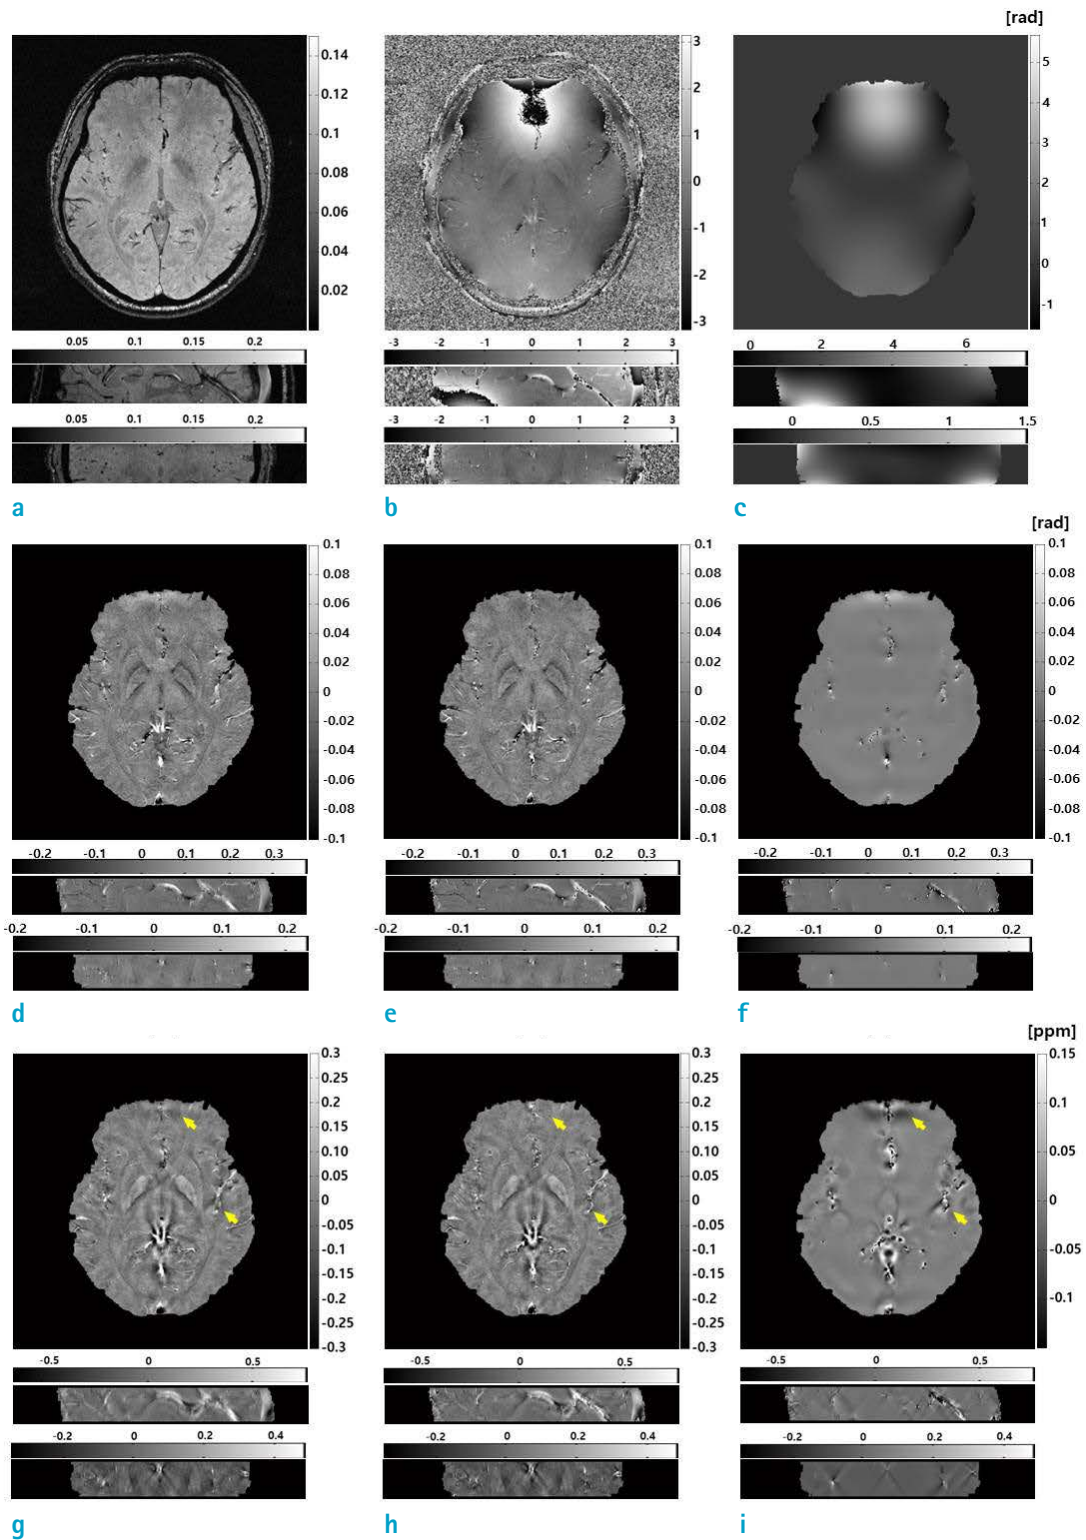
In vivo* QSM imaging at 3.0T MRI. Axial, sagittal, and coronal planes are shown from top to bottom: (a) Magnitude images, (b) wrapped phase images, (c) estimated global inhomogeneity by SUPER, (d) and (e) tissue susceptibility-induced phases without and with the global inhomogeneity correction, respectively, (f) difference, (g) and (h) susceptibility maps without and with the global inhomogeneity correction, respectively, and (i) difference. Distinctly different regions in the susceptibility maps are marked with small arrows.
